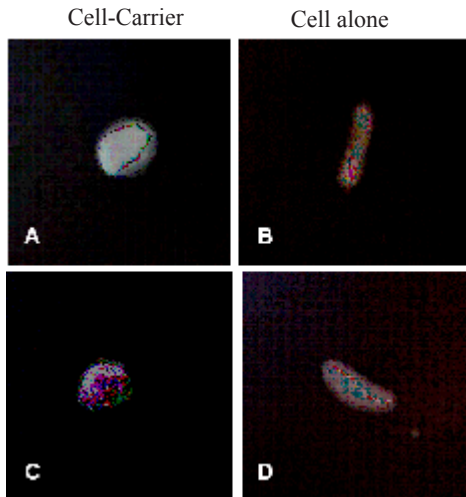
Soft X-ray photograph of Cells-Carrier and Cells alone after implantation. Cells-Carrier at 2 weeks (A) and 4 weeks (C) showed larger radiopacity compared to cells alone at 2 weeks (B) and 4 weeks (D).
